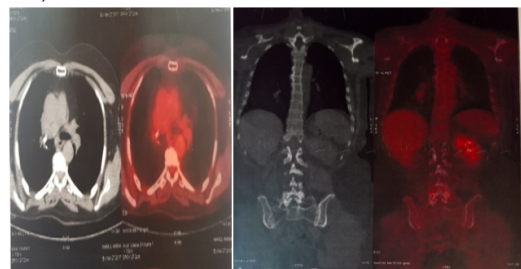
Whole body PET/CT show in the absence of uptake of the radiotracer fluorine-18 fluorodeoxy-glucose at the all volume explored
